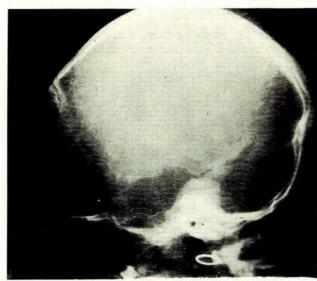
Lateral X-ray of the skull showing basal ganglia calcification.
